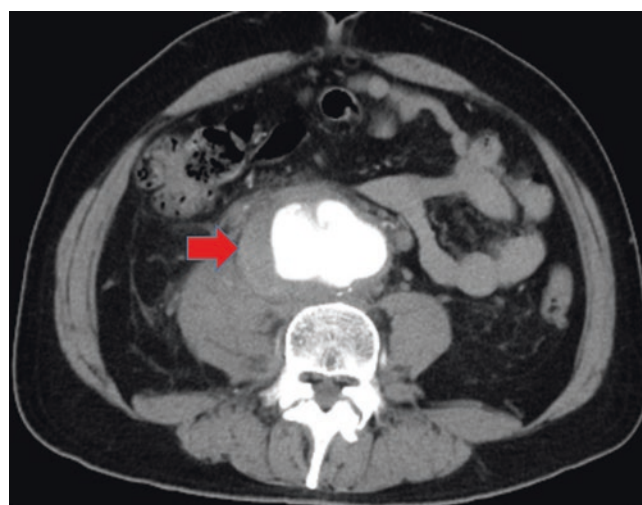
Enhanced abdominal CT image
